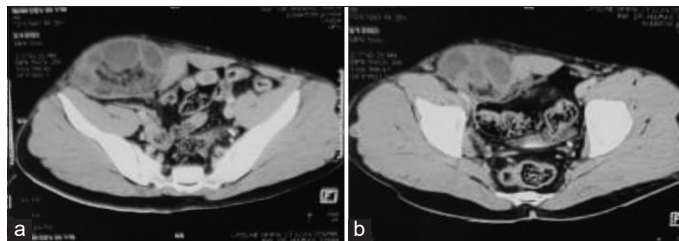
Contrast-enhanced computed tomography whole abdomen showing bowel segment entrapped within sac in abdominal wall
